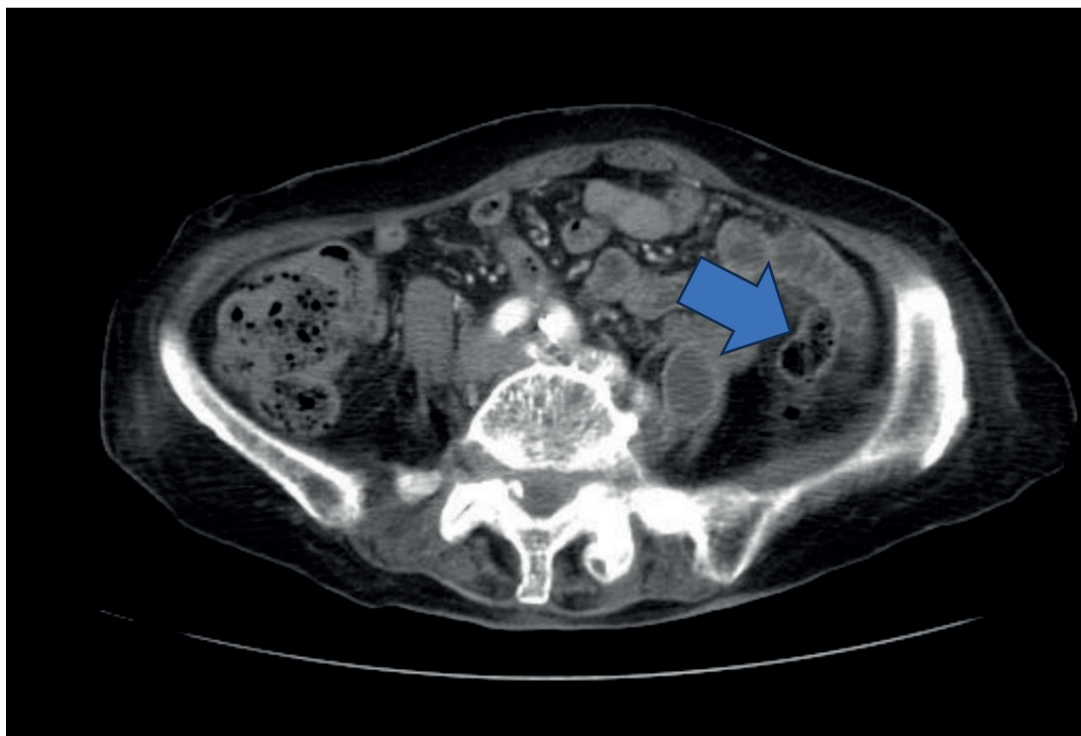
Abdominal imaging Computed tomography findings. The blue arrow indicated iliopsoas abscess.
